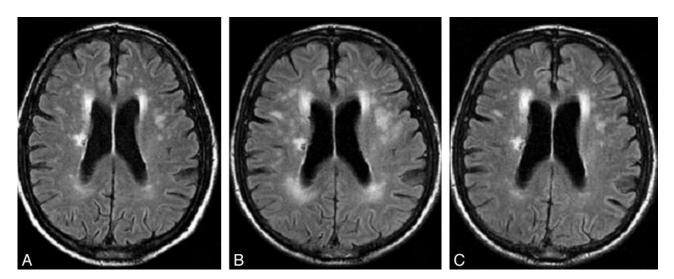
A, Baseline MR imaging study (transverse fast FLAIR T2-weighted image) of a 56-year-old patient with hepatitis C cirrhosis without overt hepatic encephalopathy. Multiple focal WMLs in both cerebral hemispheres are attributed to small-vessel disease. B, A new scan obtained 2 years later during an episode of hepatic encephalopathy shows marked increase in the size of these focal WMLs. C, A new follow-up scan after complete resolution of neurologic symptoms shows a decrease in the size of the WMLs. This last scan was almost identical to the first study. A lacunar infarct is seen in the deep right frontal white matter.
